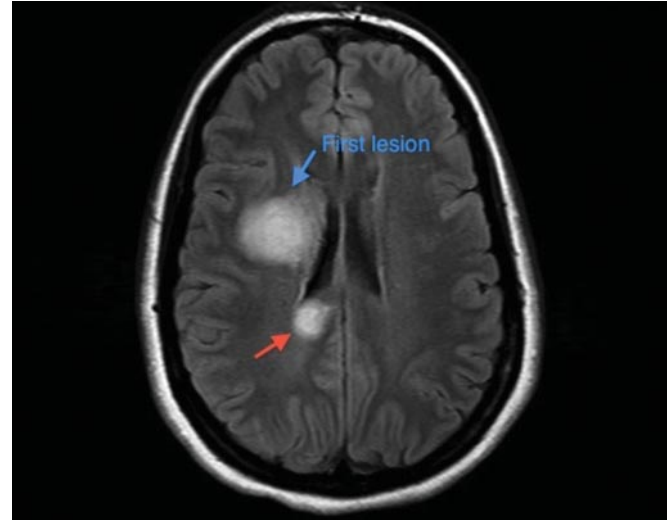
Axial T2-weighted fluid-suppressed MRI roughly at the level of dorsal caudate, splenium and genu of the corpus callosum, showing the inferior aspect of the large lesion and a small, hyperintense ovoid lesion in the splenium of the corpus callosum.
